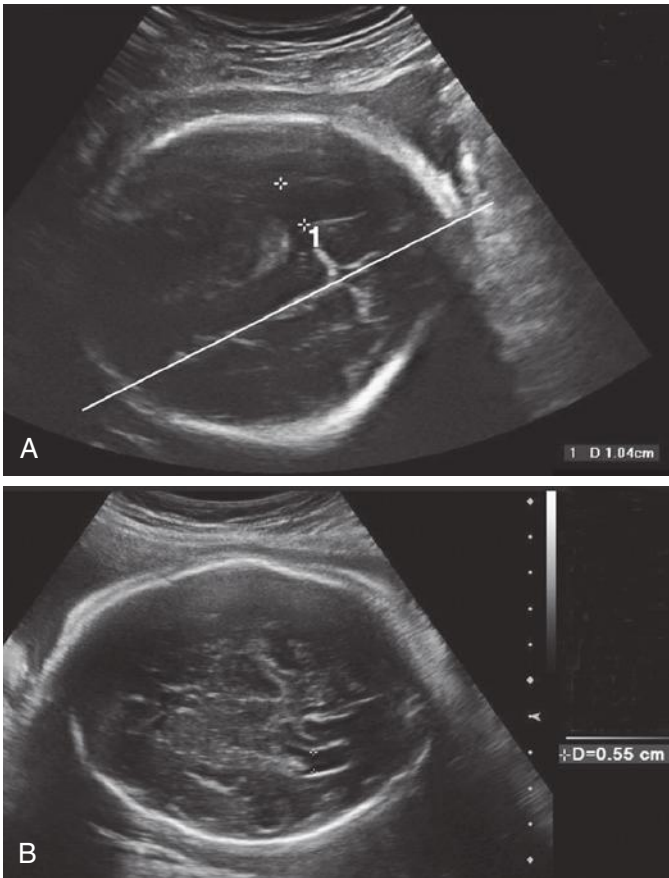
A, A patient was referred because a sonogram performed at 31 weeks' gestation revealed a mildly dilated cerebral ventricle. Note that the scan plan is angled (oblique axial) such that the midline (*line*) is off-center. B, When the scanning plane was corrected (true transverse axial) such that the brain anatomy appeared symmetric, the lateral ventricle is shown to be of normal size.
